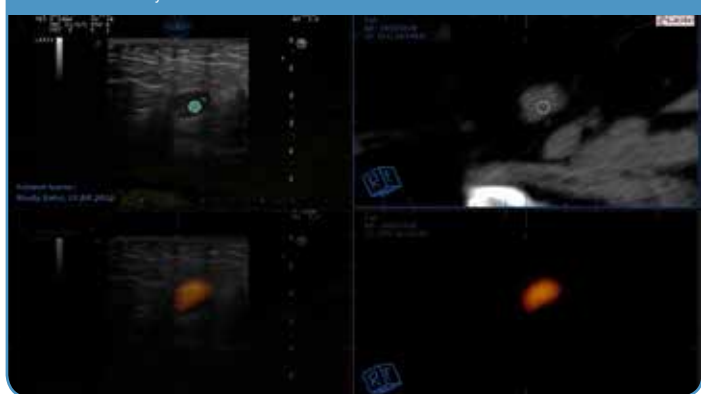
Fusion of US, CT and PET in a patient affected by uterine sarcoma
